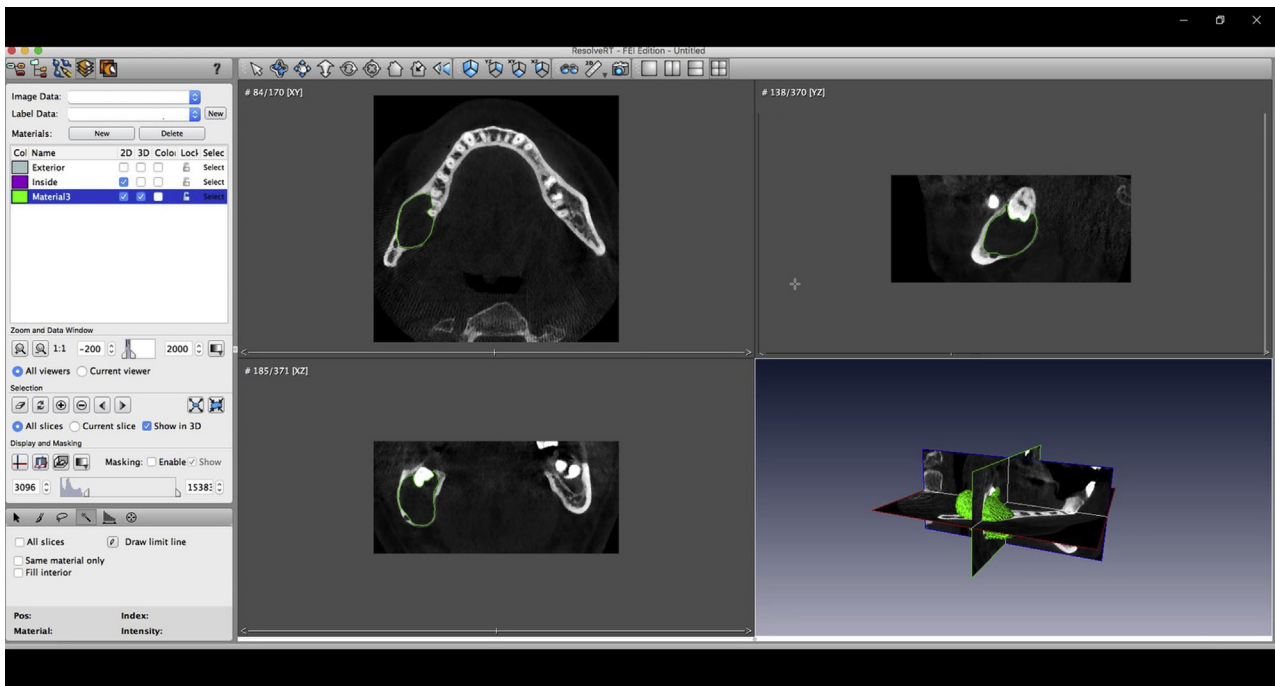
Cone-beam computed tomography scan showing segmentation procedure and volumetric measurements of the dentigerous cyst before marsupialization. The lesion profile is outlined on each slice in 3 spatial planes, providing a 3-dimensional rendering of the affected portion.
